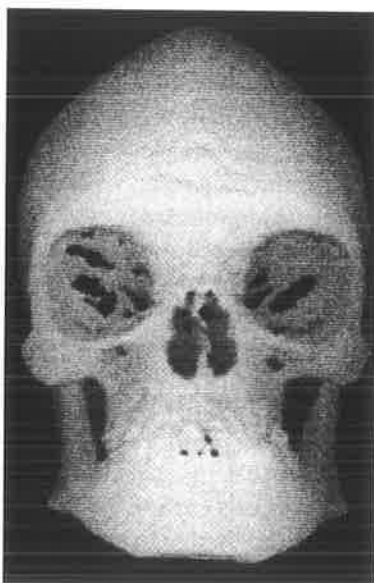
Method of specifying CT scans with thin slices in the area of interest and thicker slices in reference area or area of anatomical context.
